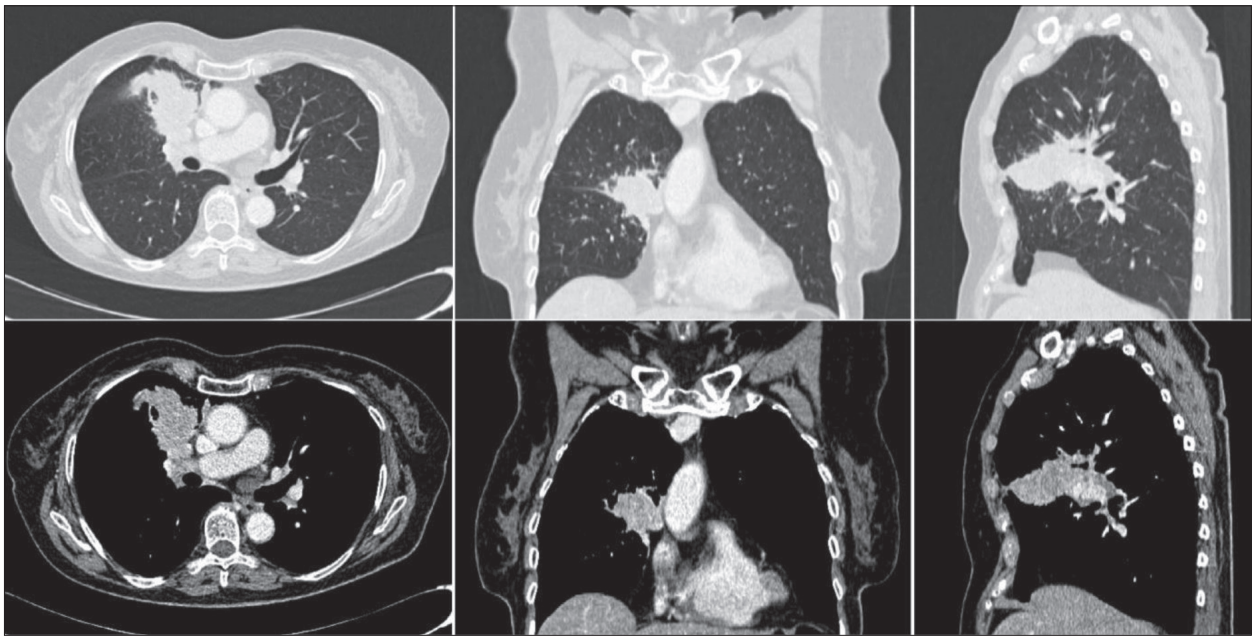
Initial chest CT at the time of diagnosis
